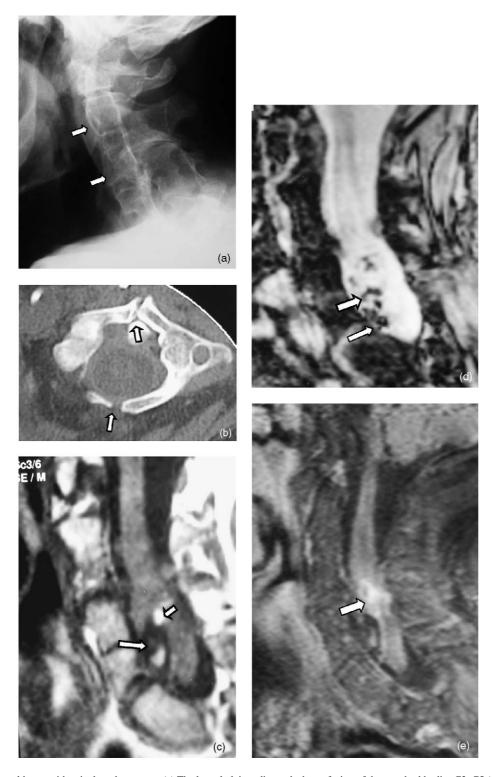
Sixty-two-year-old man with spinal cord teratoma. (a) The lateral plain radiograph shows fusion of the vertebral bodies C3–C5 (arrows). (b) The axial CT image shows congenital non-union of C1 both anteriorly and posteriorly (arrows). (c) The sagittal T1-w Spin Echo MR image shows expansion of the cord together with hyperintense foci compatible with fat (arrow) and low signal intensity lesions compatible with calcifications (short arrow). The spinal cord is not well demonstrated in the lower cervical spine because of scoliosis. (d) The sagittal T2-w gradient echo image shows susceptibility effects confirming, thus, the presence of calcifications (arrows). (e) The sagittal contrast enhanced fat-suppressed T1-w Spin Echo image shows expansion of the cord together with abnormal enhancement of the solid part of the tumor (arrow).
